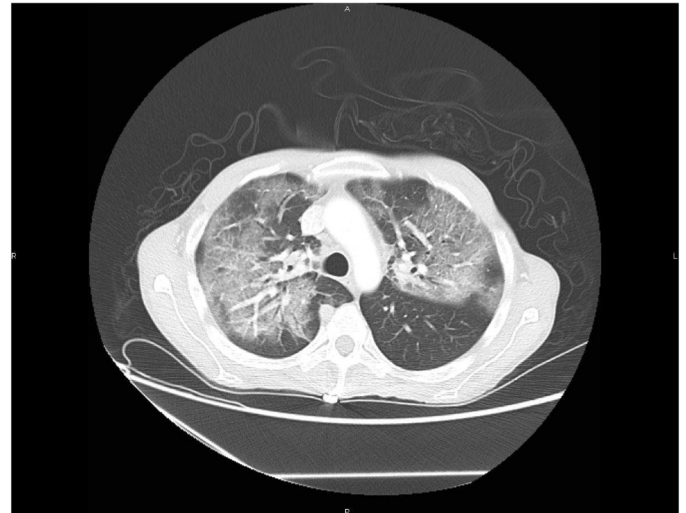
Lung computed tomography scan at Day 5, showing alveolar and interstitial pneumonia.
